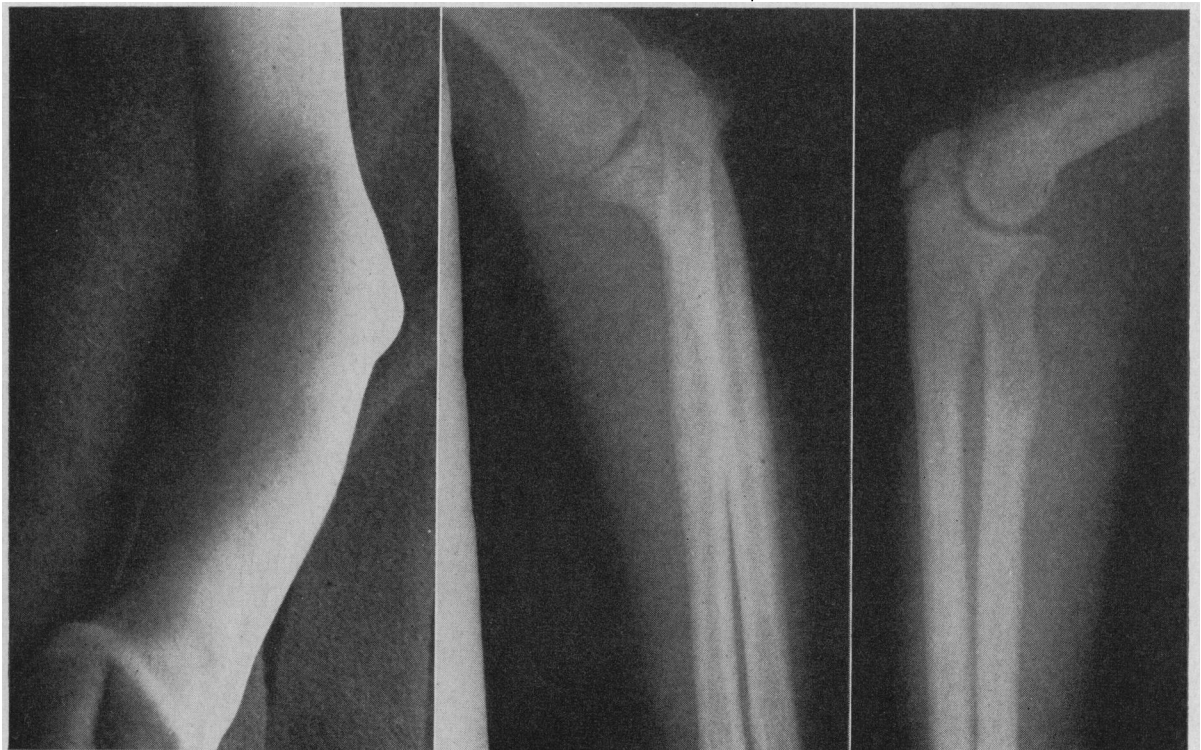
Left: Deformity of elbow (Case 2). Center: X-ray film of deformed elbow. Right: X-ray film of normal right elbow, same patient.
